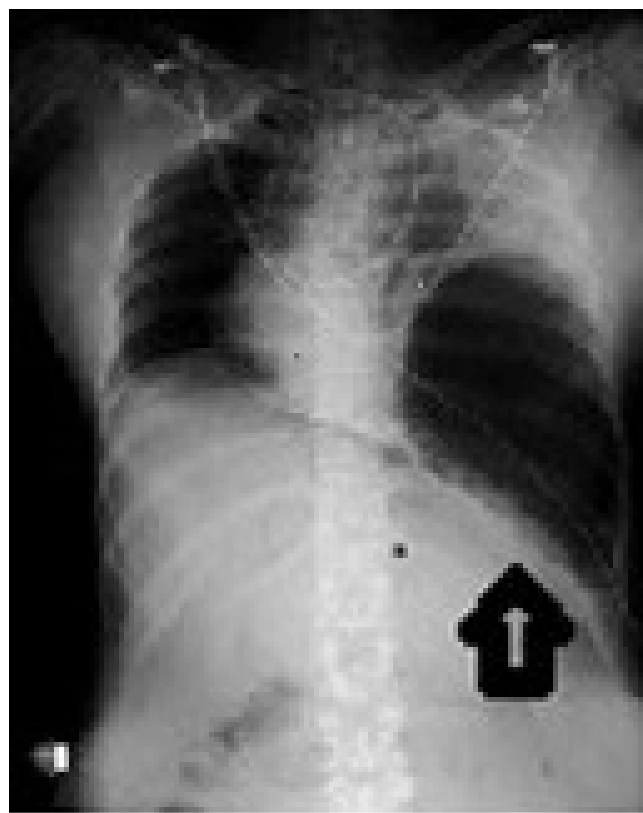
The patient's chest x-ray exhibited free air trapped in the left lung basal area.
